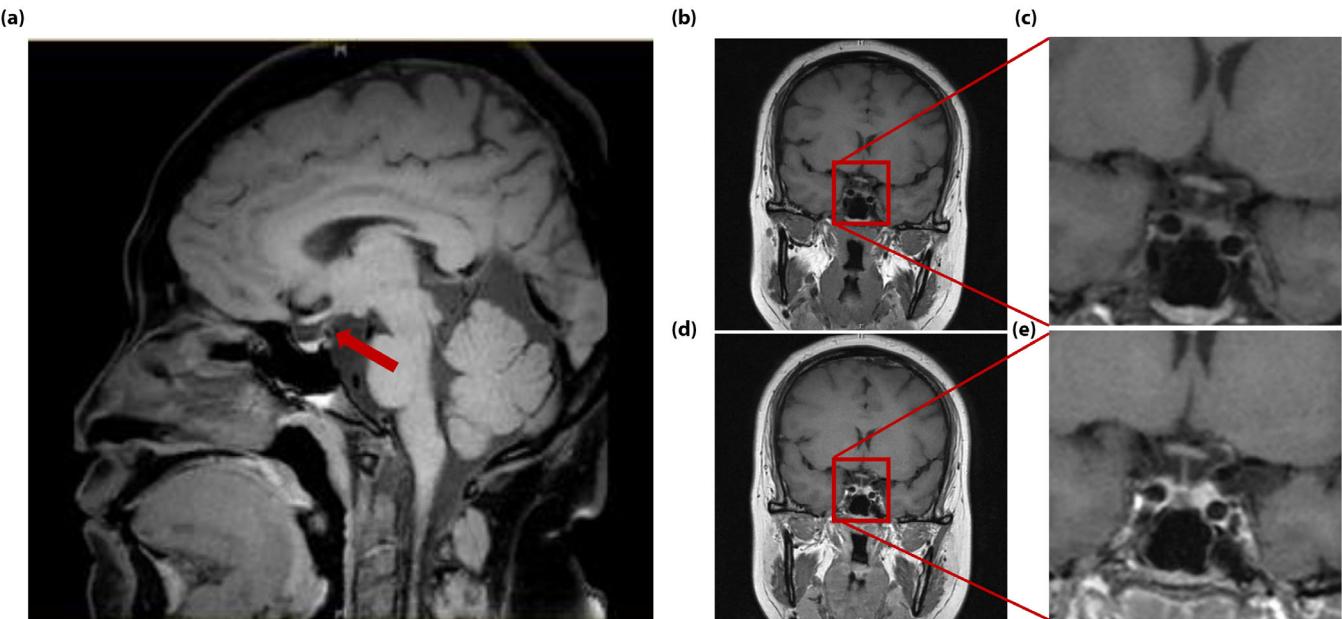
Representative images of brain magnetic resonance imaging (MRI) focused on the pituitary region.
